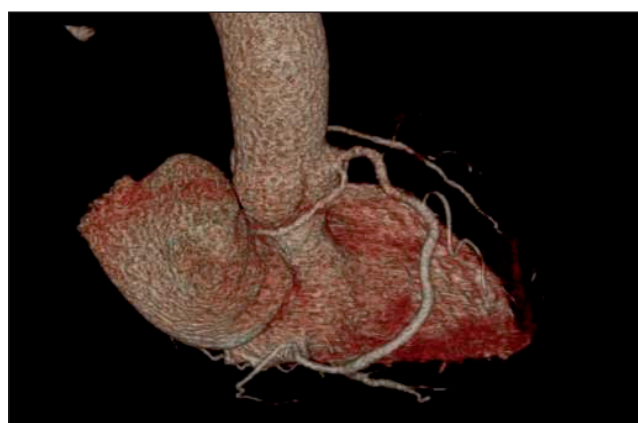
3D volume rendered multi-detector CT image showing anomalous origin of LCx from right sinus of Valsalva with a retroaortic path.
